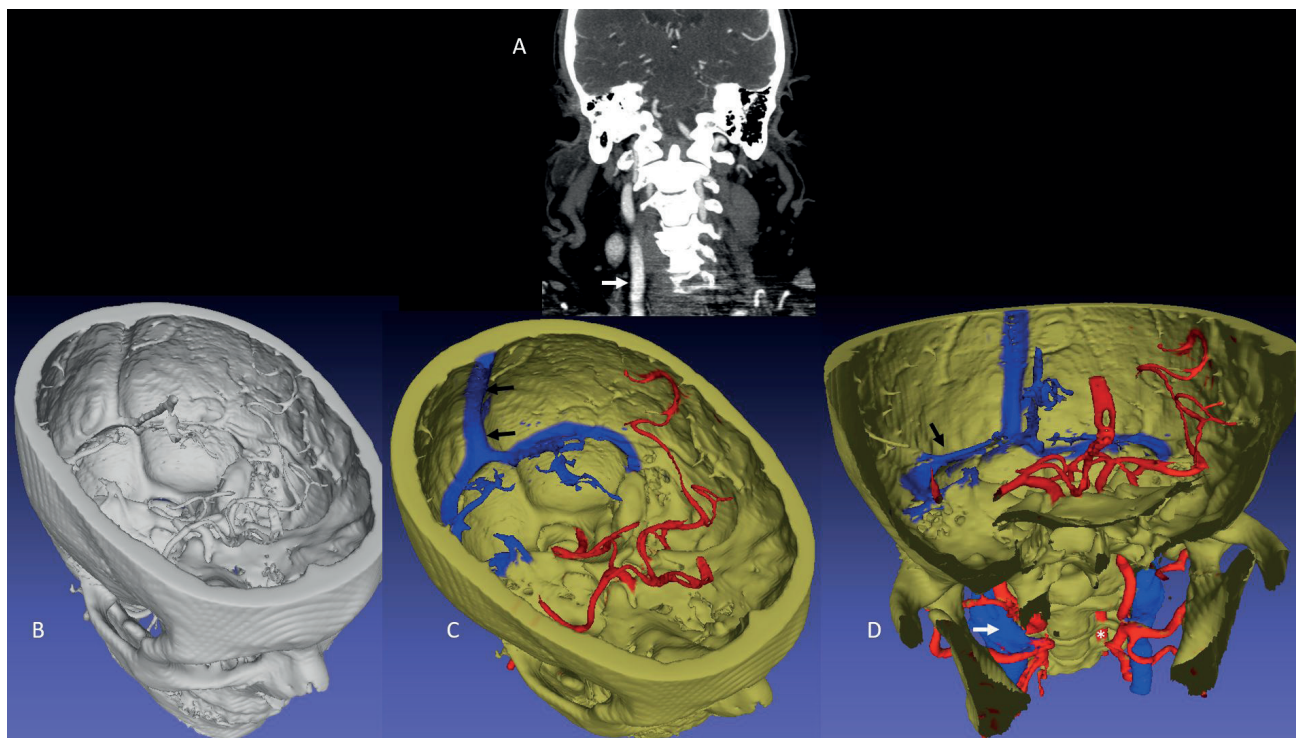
Craniocervical CT angiogram (A) in a patient with vertebral artery dissection. Images B, C and D are preparations made by the students from CT angiography, aimed to show the encephalic vascularization and its relationship with the bone. Black arrows show parts of venous circulation. White arrow in D points to jugular vein. These latter structures were segmented and depicted by students, as a part of their learning of cephalic circulation.
